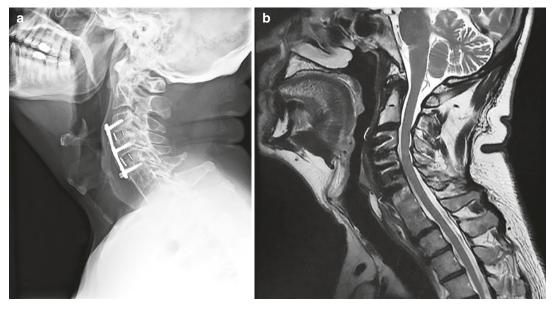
Management of adjacent segment degeneration. (a) Lateral postoperative radiograph at 4-month follow-up demonstrating the anterior cervical discectomy and fusion performed at C3–4 and C4–5. A maturing arthrodesis is becoming evident within the interbody spacers. Note that one screw at C6 has begun to pull out past the locking mechanism; this pullout remained
